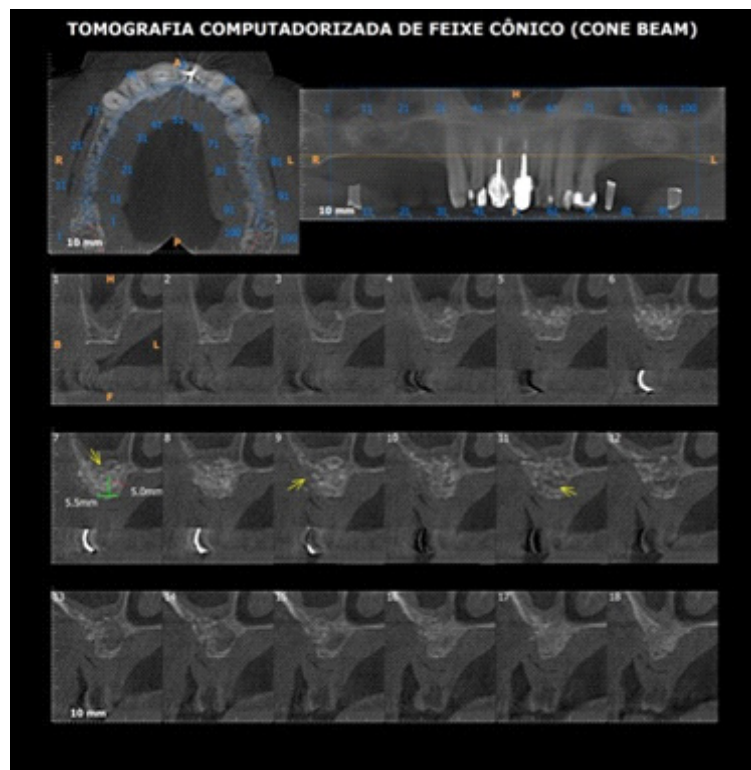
Cone Beam Computed Tomography after 06 months of the bilateral maxillary sinus lifting surgery, proving the bone increase in volume (height and thickness) in the cuts on the right side.
